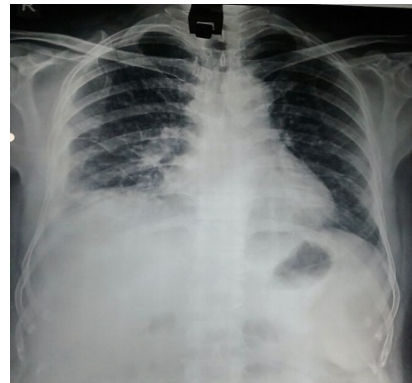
Chest X-ray showing right side pneumonitic changes.
